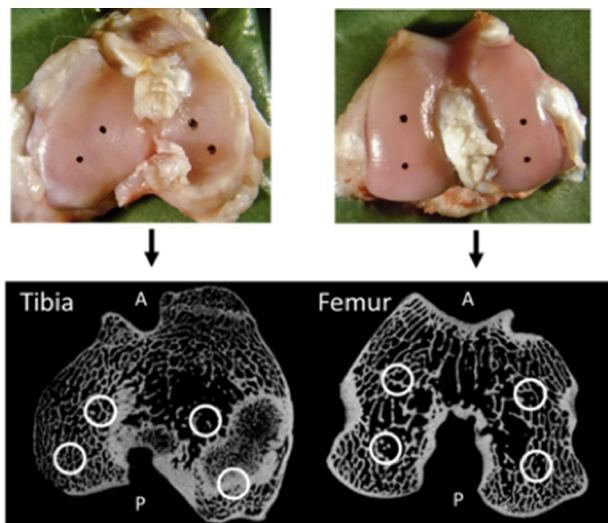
Location mechanical testing sites of the articular cartilage on the tibia and femur along with their respective locations on the microcomputed tomography images. A—anterior and P—posterior.
